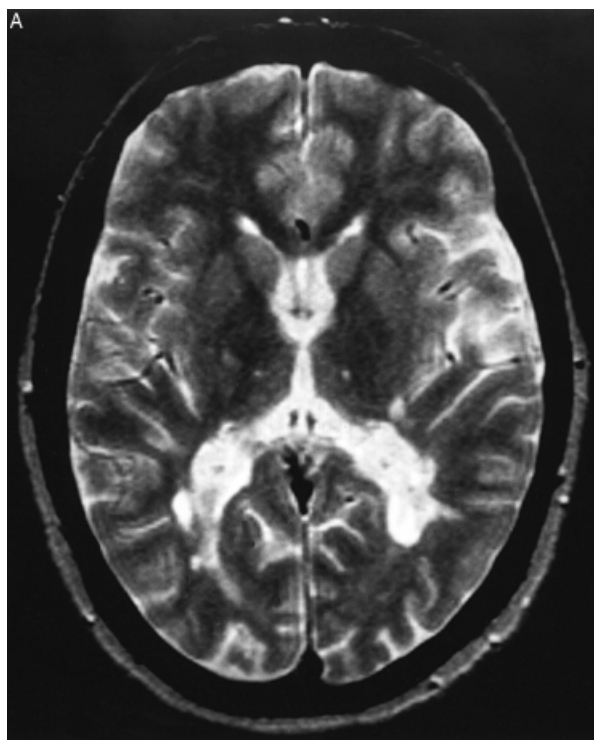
Discrete lesions in the right optic radiation and right occipital region in the postchiasmatal visual pathway shown as (A) high signal lesion on T₂-weighted brain MRI and corresponding (B) low signal hypointensity ('T₁ hole') on T₁-weighted MRI, and (C) hyperintensity on proton-density-weighted MRI.
